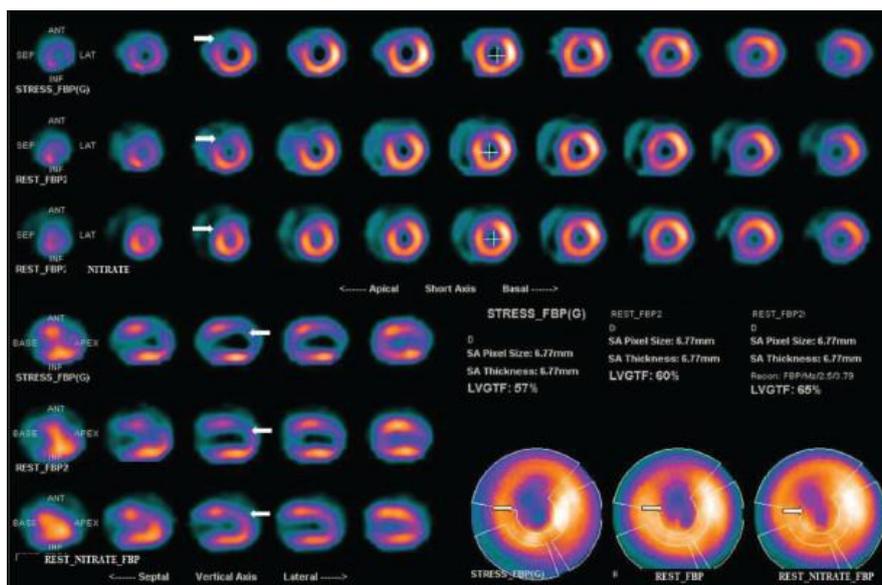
Myocardial scintigraphy
